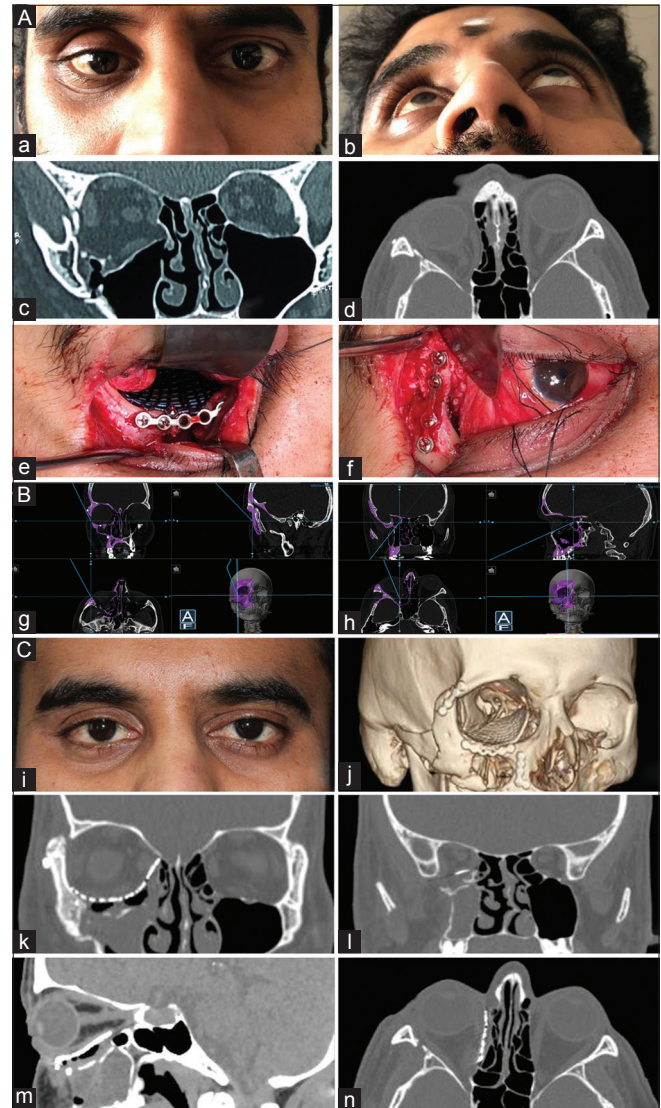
(A) (a and b) Clinical picture showing enophthalmos right eye and loss of malar eminence. (c and d) CT scans showing inadequately reduced zygoma and orbital floor and medial wall fractures (surgery by another surgeon). (e and f) Intraoperative pictures after reduction and fixation showing the implants used. (B) (g and h) Navigation pointer placed on the zygoma and orbital implant showing proper reduction and implant position corresponding with the mirrored image. (C) (i-n) Postop CT scans and clinical picture showing the implant position and symmetry with opposite side and significant improvement in enophthalmos and malar prominence
